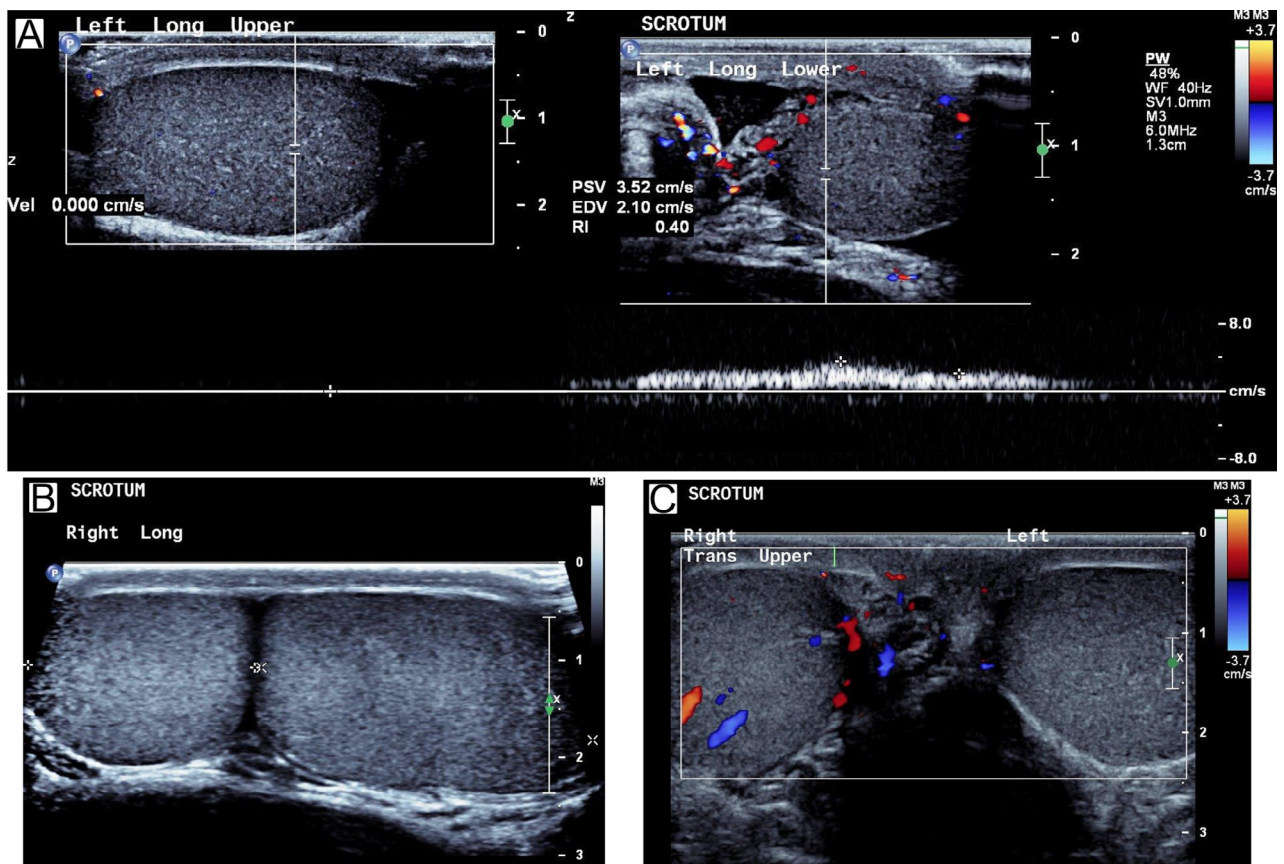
Scrotal ultrasonography; (A) left hemiscrotum (longitudinal section) with corresponding Doppler measurement, demonstrating absent blood flow in upper left testis, and diminished vascularity in left lower testis; (B) right hemiscrotum (longitudinal section) demonstrating 2 testes; (C) transverse section across upper scrotum showing right and left upper testes, demonstrating normal and reduced/absent blood flow, respectively. (Color version available online.)
